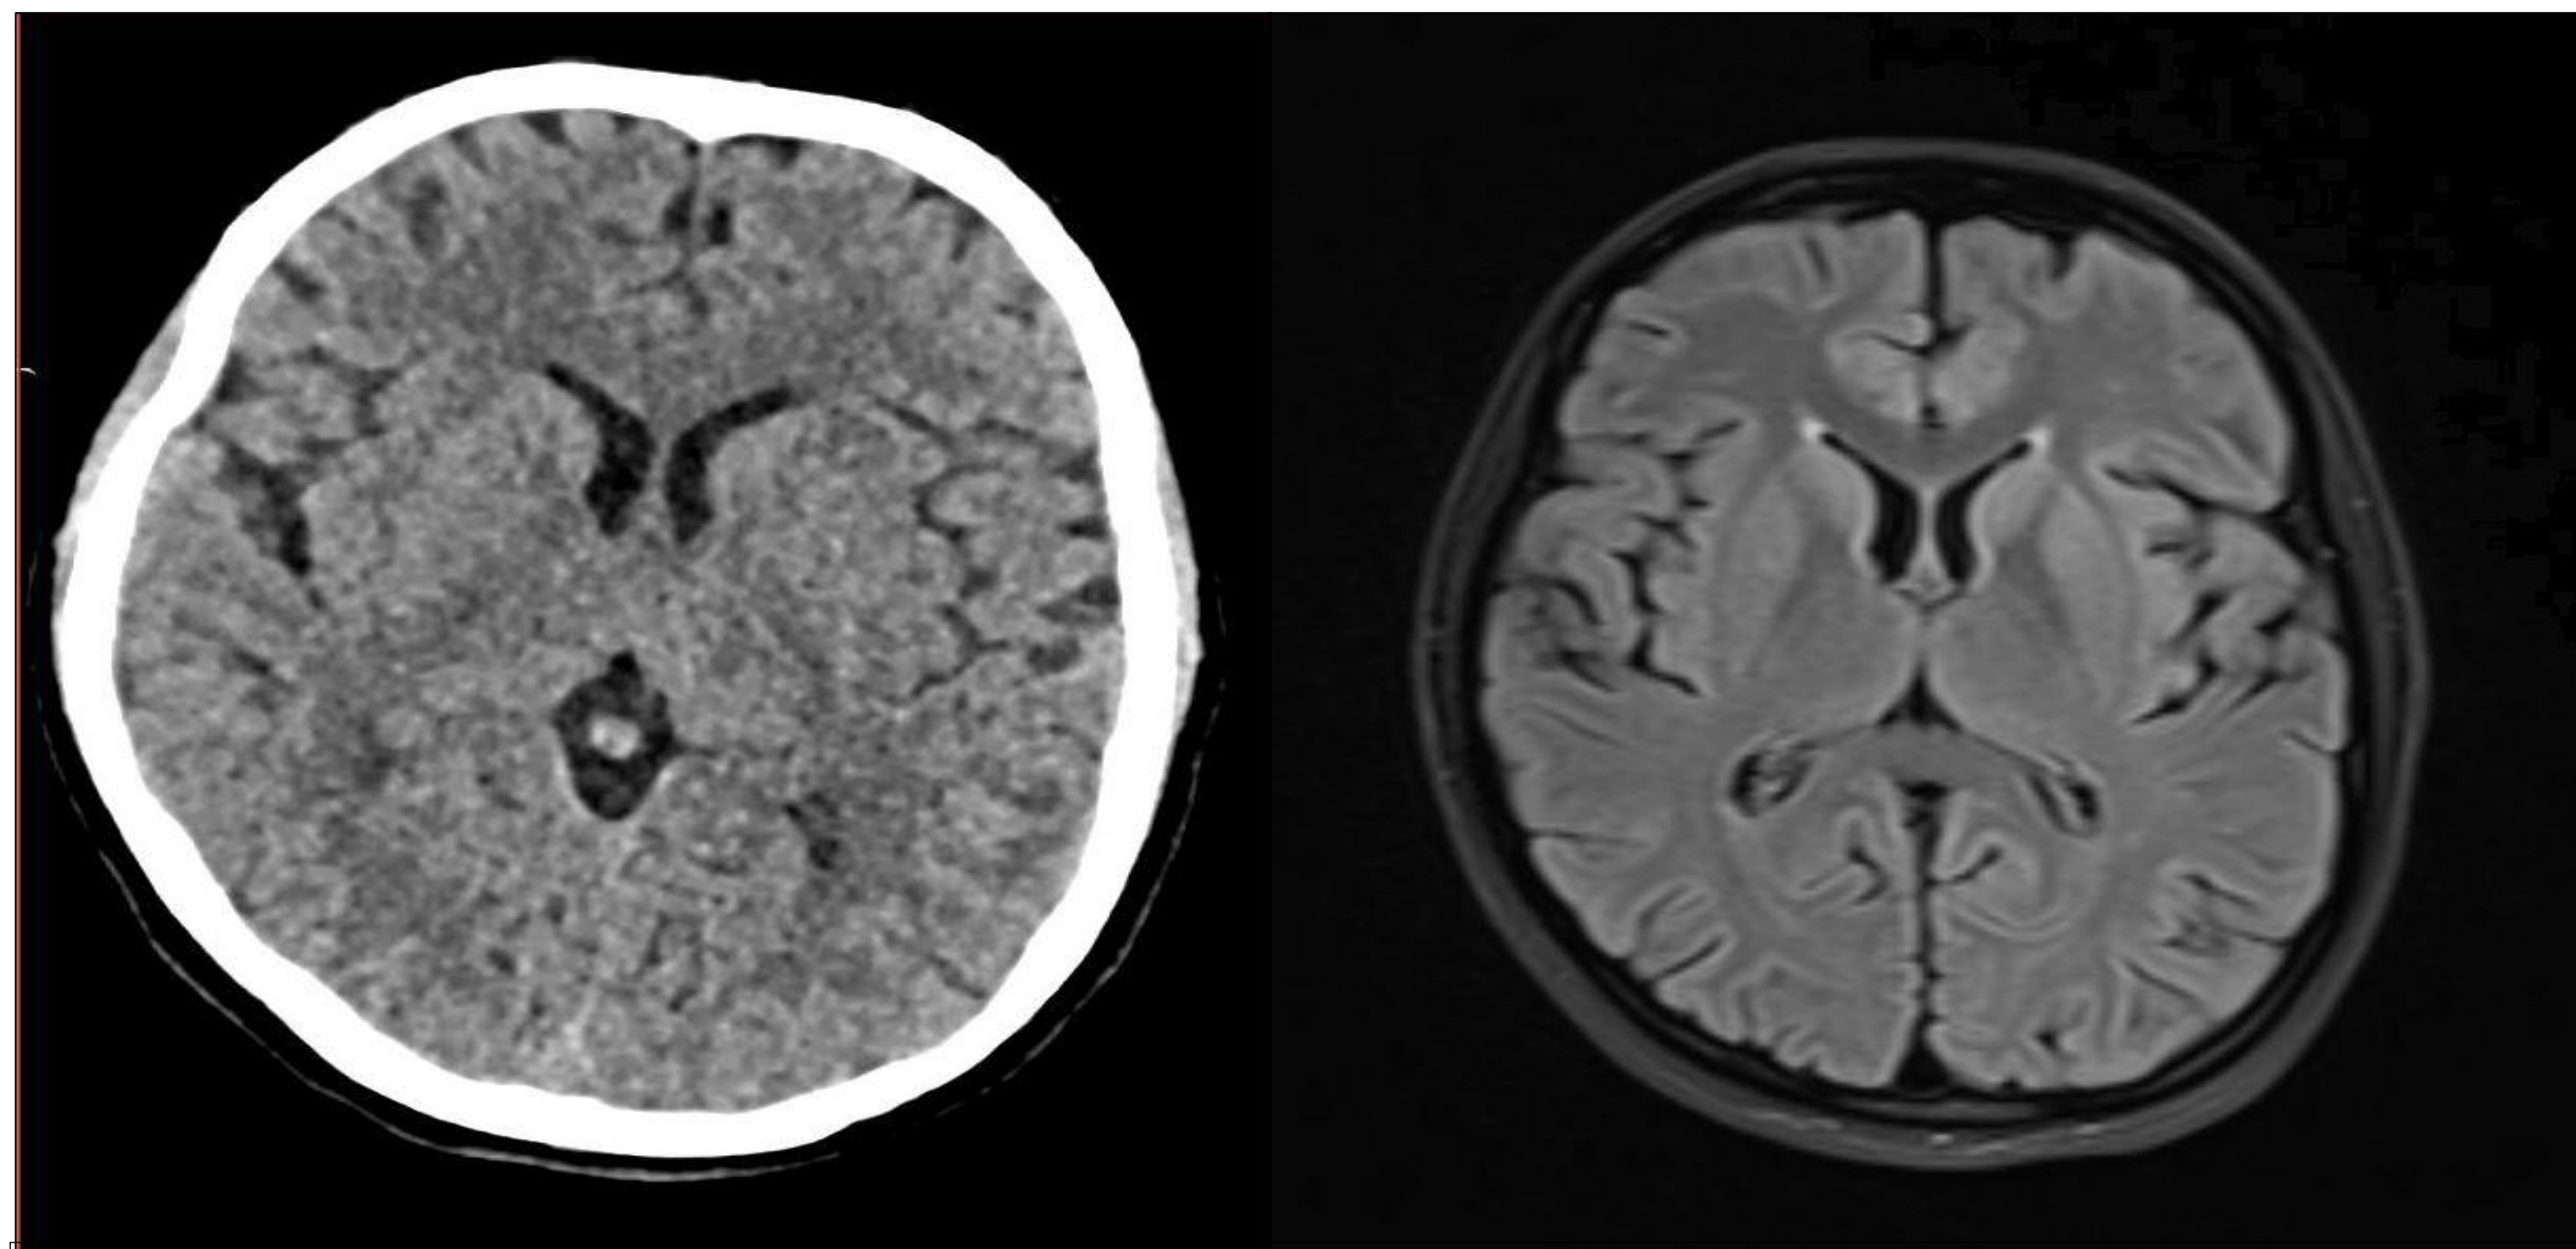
Axial section of CT-Brain and FLAIR MRI Brain revealed no structural brain defect, or anomaly to which seizure activity could be attributed.
